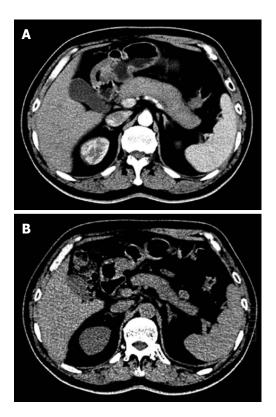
Typical imaging features of type 1 autoimmune pancreatitis. Computed tomography (CT) scan showing diffuse swelling of the pancreas with loss of lobulation (A), and a dramatic decrease in swelling of the pancreas after 3 wk of steroid treatment (B).
